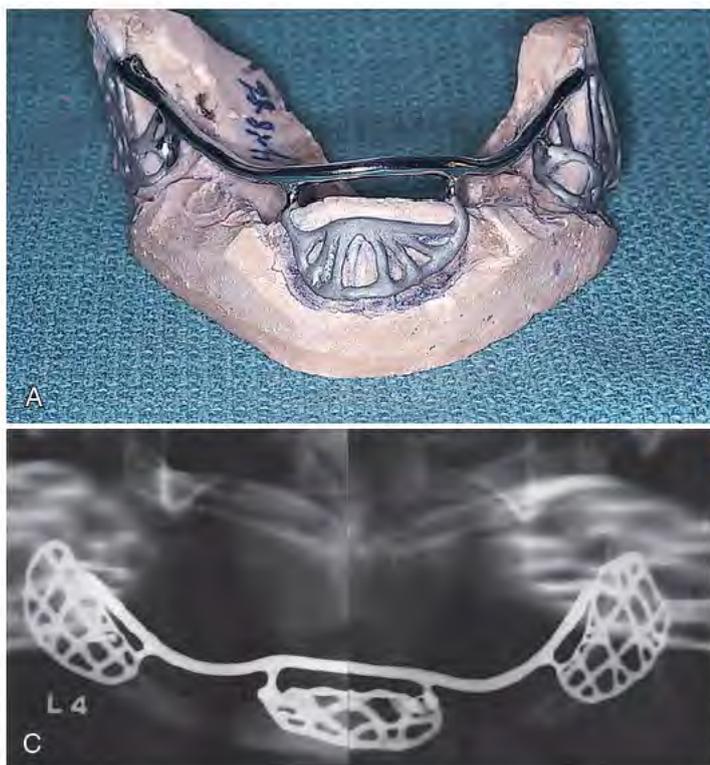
A, The tripodal design has few crestal elements and a significant symphyseal component. B, The rami are sites of vital support. As they come closer together during jaw opening, tension that stimulates a dynamic osseous environment and ongoing bone remineralization is created. Two points of permucosal penetration are found at each posterior end: the first is horizontal to the ramus, the second is vertical to the retromolar pad. Either of these may be resected if the need arises. C, A Panorex radiograph demonstrates the dramatic extension of the tripodal islets and the bar configuration.
